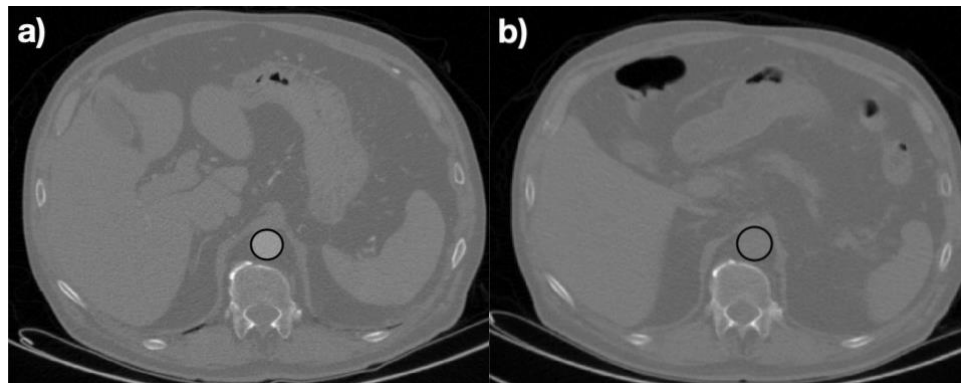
Transaxial images of CT showing ROI on aorta(a) and on calcification (b).
